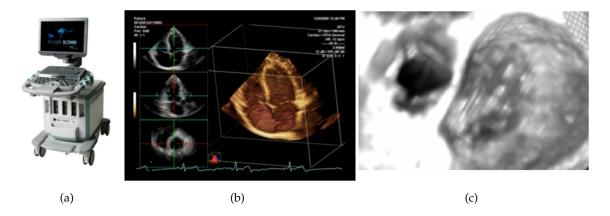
(a) Siemens SC2000 ultrasound machine, (b) TTE four chambers image of the heart, (c) TEE volumetric reconstruction of the mitral and aortic valves.
